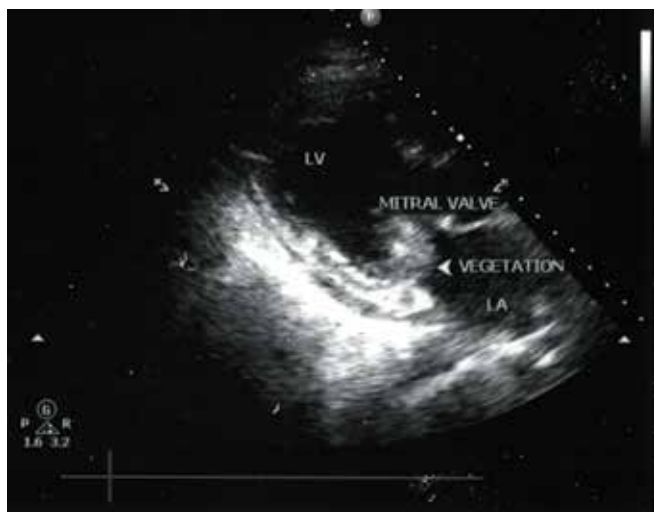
Echocardiogram showing the size and position of the vegetation.
